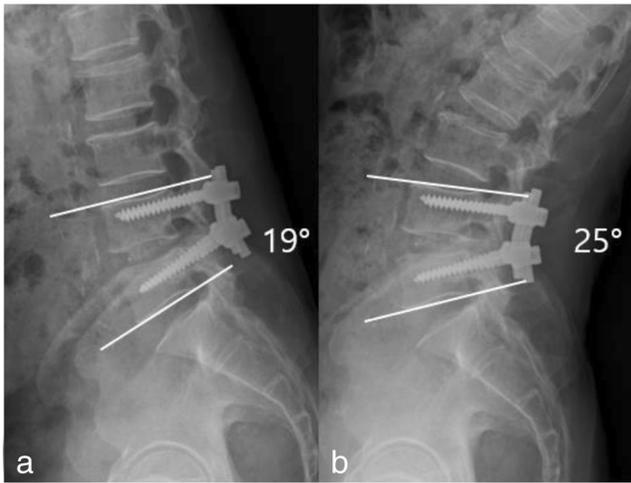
Measuring angular motion with dynamic plain radiographs. a Flexion radiograph and b extension radiograph, showing more than 5° of angular motion
